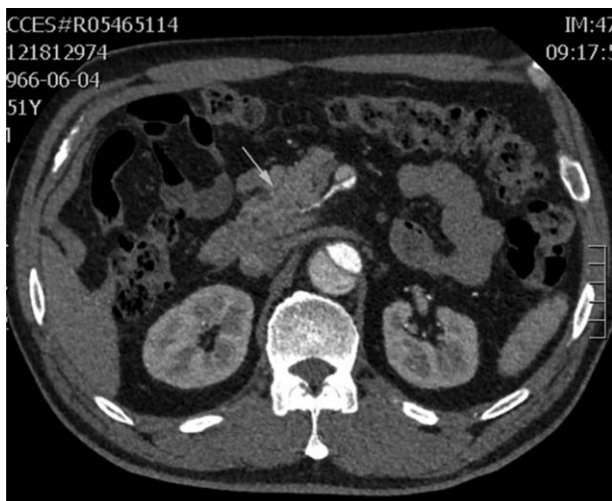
Follow-up CTA at 3 months later showed SMA branch pseudoaneurysm disappeared. CTA = computed tomography angiography, SMA = superior mesenteric artery.
